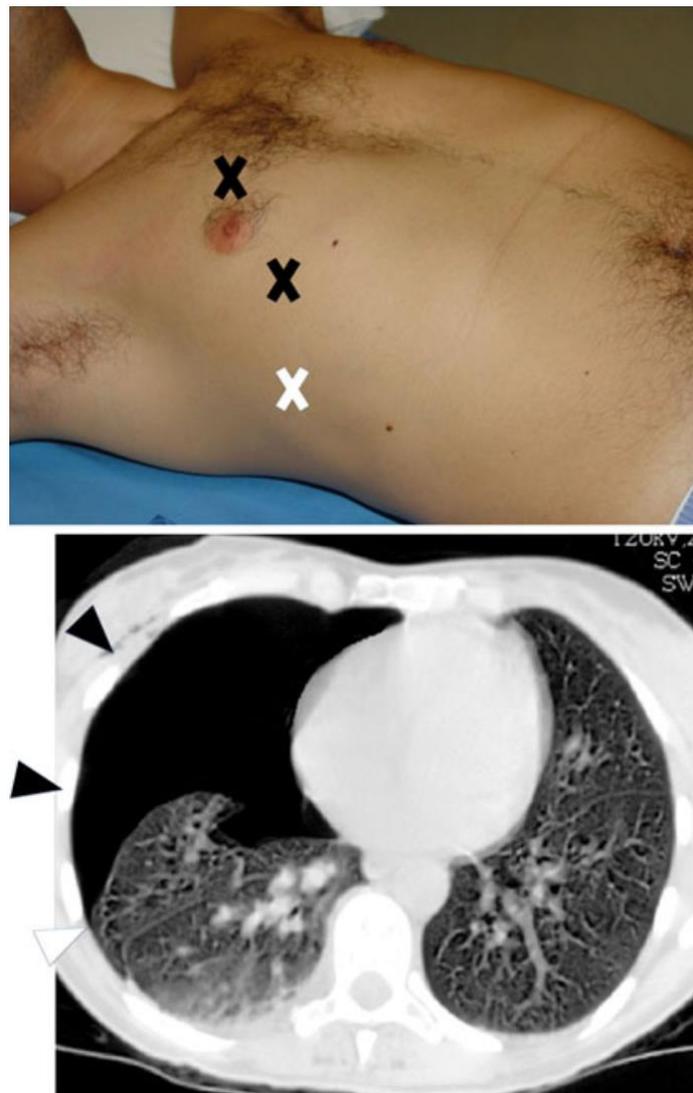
Upper panel: when there is absence of sliding and B-lines in the anterior chest (black crosses), the probe is moved to the lateral areas looking for sudden visualisation of a respiratory pattern (appearance of sliding and B-lines), the lung point (white cross). Lower panel: corresponding CT scan showing right sided pneumothorax. The black arrows show two chest areas where lung sliding cannot be visualised. The white arrow indicates the area where sliding is visualised again, the lung point.
